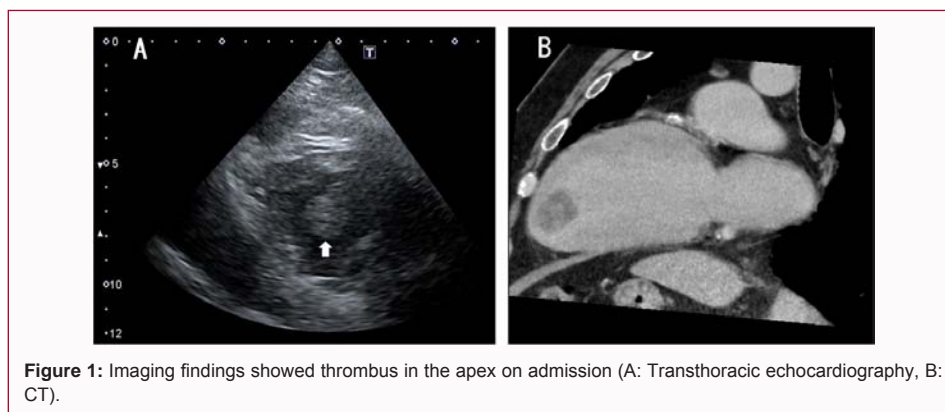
Imaging findings showed thrombus in the apex on admission (A: Transthoracic echocardiography, B: CT).
